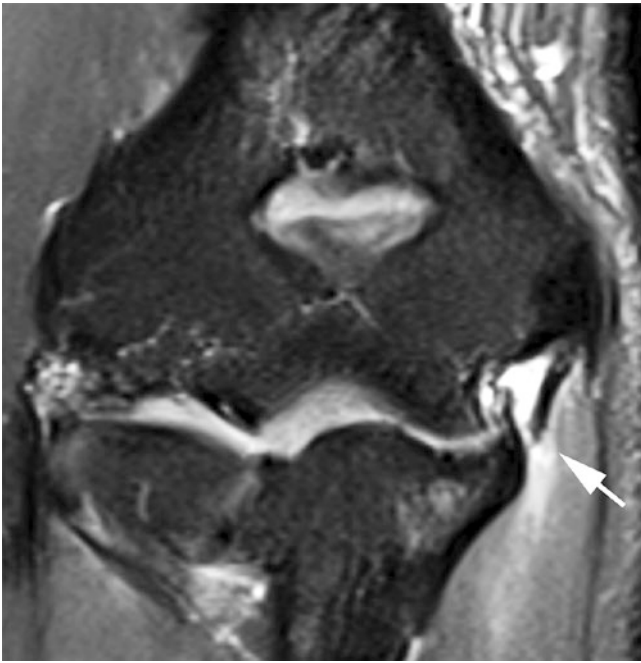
Ulnar collateral ligament tear. An 18-year-old college baseball pitcher who felt a “pop” in his elbow while throwing and presented with medial elbow pain. Coronal fat-saturated T2-weighted image reveals a full-thickness tear of the anterior bundle of the UCL at its ulnar attachment (arrow) and edema in the adjacent flexor musculature (arrowhead)
